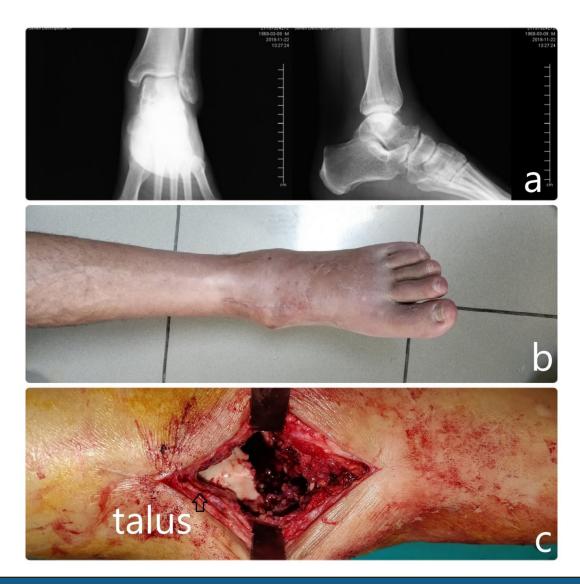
Anteroposterior and lateral ankle radiography (a), Ankle clinical photo (b), intraoperative ankle anteroposterior photo (c)
